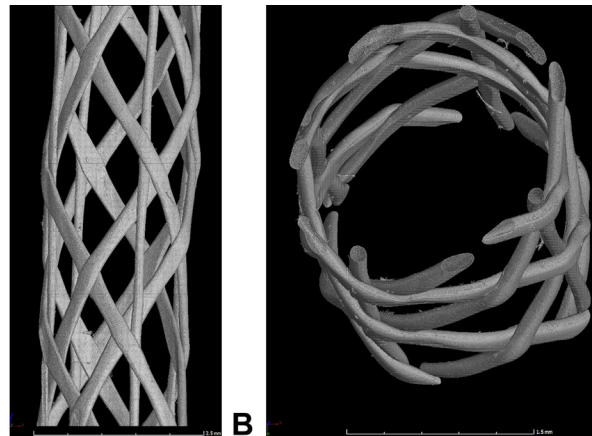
A, B Micro computed tomography demonstrates the cross-hatch design and increased surface area of the mesh suture.
